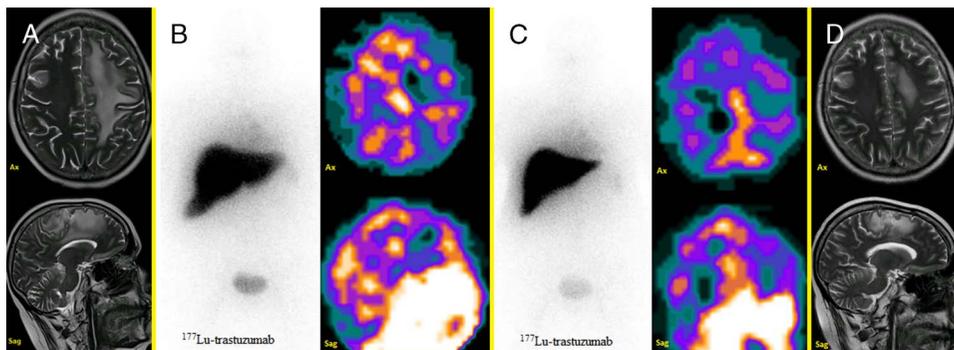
A 46-year-old woman with HER2-positive breast cancer and brain metastasis observed on MRI (A) refractory to conventional therapy methods underwent 2 cycles of ¹⁷⁷Lu-trastuzumab (Herceptin) (3.7 GBq). Posttherapy scintigraphy after the first cycle of ¹⁷⁷Lu-trastuzumab (Herceptin) (B) showed intensive radiotracer uptake in the lesion and in its periphery, which decreased in posttherapy scintigraphy of the second cycle (C). Also, brain MRI done 2 weeks after the second cycle of therapy revealed a remarkable decrease in the peripheral lesion (D).
